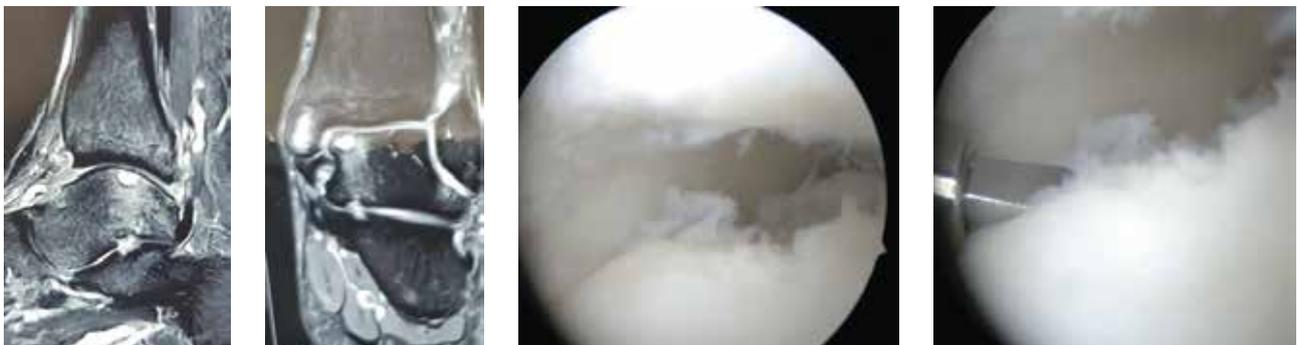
MRI and arthroscopic images of a 31-year-old footballer who was treated by microfracture and returned to play after 9 months.
